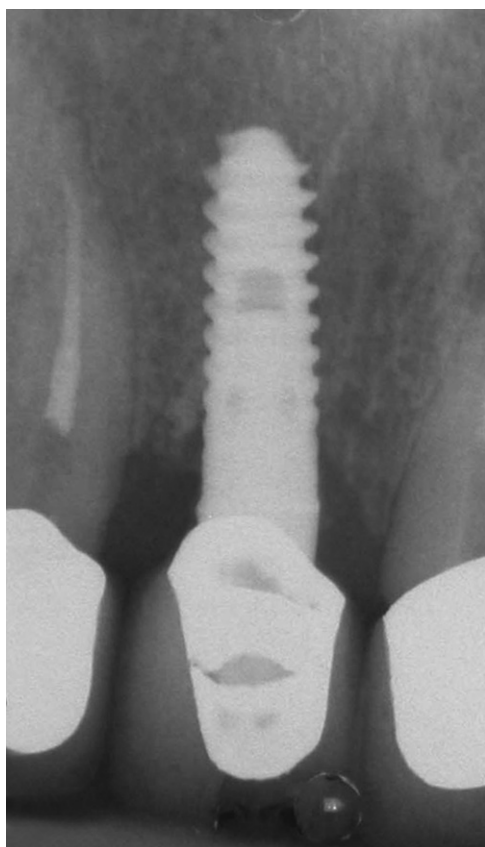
Postoperative radiograph of implant, after immediate loading.
